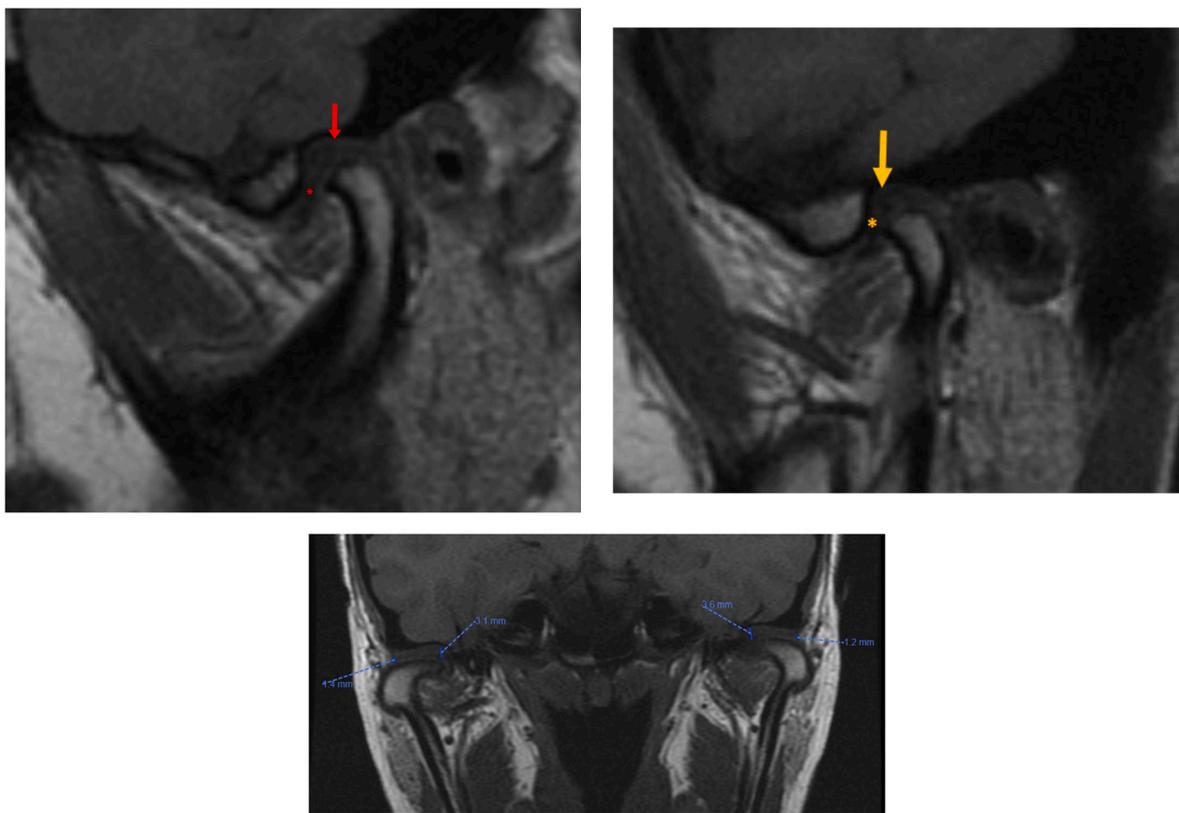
T1 weighted MRI views. A. Right sagittal view showing mild anterior displacement of the disc (red asterisk). Junction of the disc and retrodiscal tissue marked with red arrow. Mild degenerative changes also seen in the condyle. B. Left sagittal view with similar findings as the right side (yellow asterisk on disc, yellow arrow pointing to junction of disc and retrodiscal tissue). C. Coronal view showing normal appearing position of the discs (measurements of thickness at the medial and lateral aspects shown).
